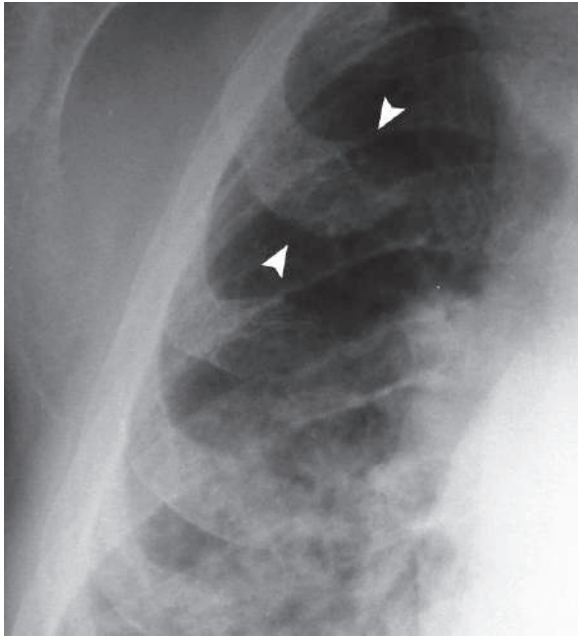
AP plain radiograph shows expansion of the ribs due to extramedullary hematopoiesis (*arrowheads*)
